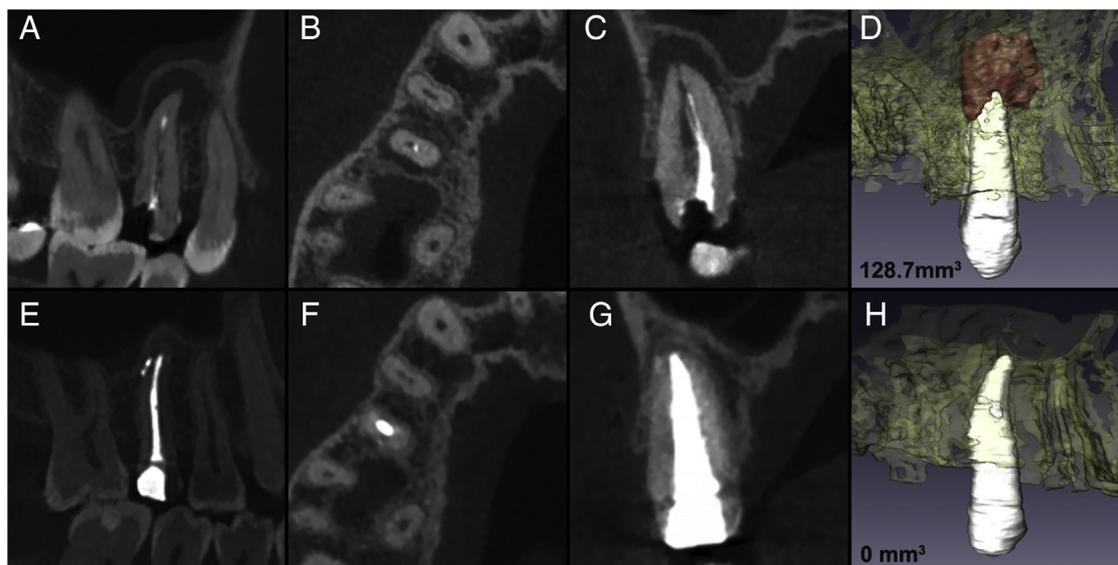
Reconstructed images in multiplanes and 3 dimensions based on CBCT scans (A–D) preoperatively and (E–H) at the 4-year recall of tooth 15. (D) The preoperative periapical lesion with a volume of 128.7 mm³ had completely resolved (H) at the 4-year follow-up.
